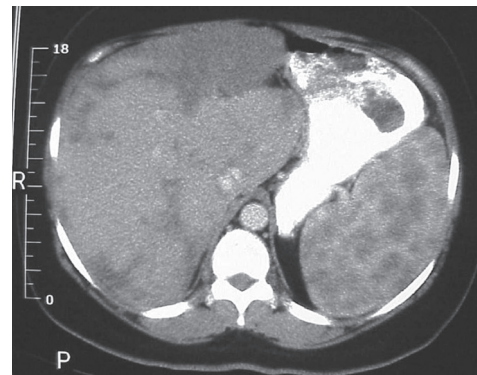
CT scan of the abdomen after oral and intravenous contrast. The stomach is compressed by the enlarged spleen. Within the spleen, areas of hypo- and hyperdensity are identified.
